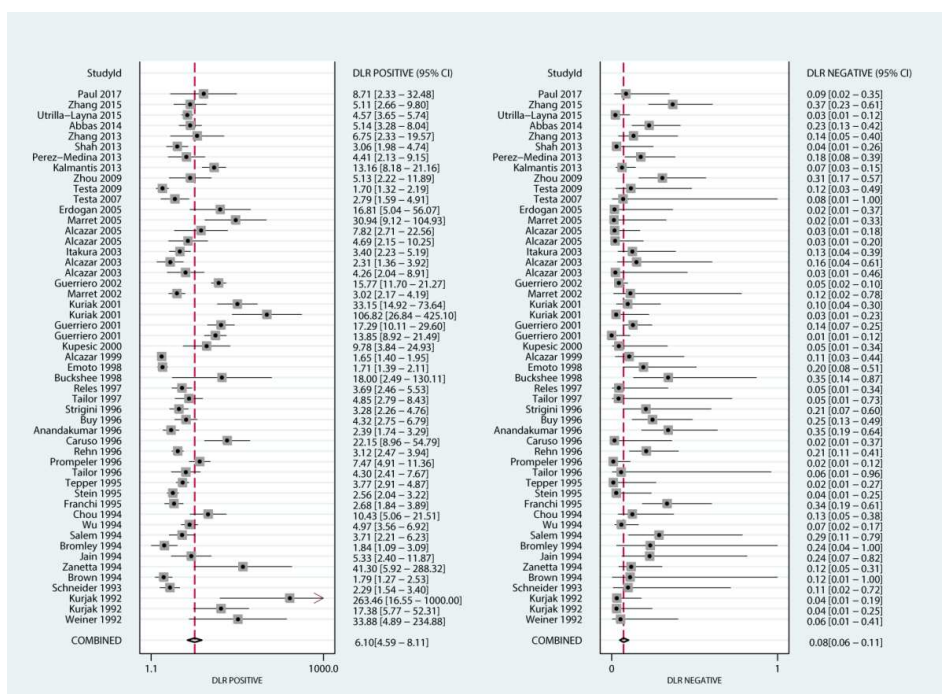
The pooled PLR and NLR for Doppler US differentiate the benign and malignant ovarian masses
